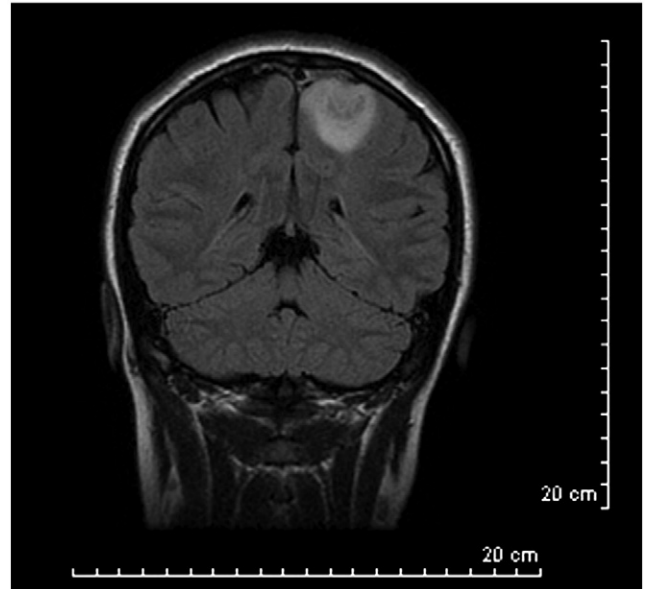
T2-weighted fluid-attenuated inversion recovery coronal MRI examination of the brain revealed a heterogeneous high-signal intraaxial lesion in the superior aspect of the left parietal lobe resulting in sulcal effacement.
